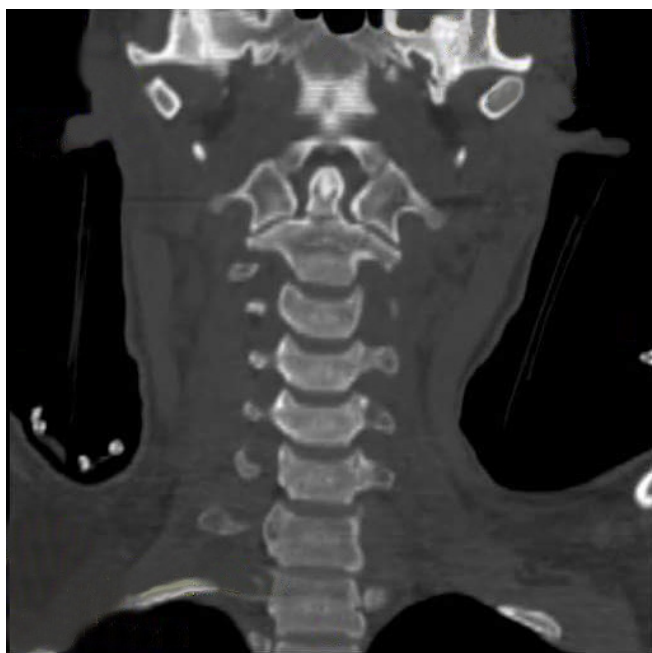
A computed tomography scan of the cervical spine in a coronal reformatted view. The image clearly shows a complete fracture at the base of the odontoid process (C2).
